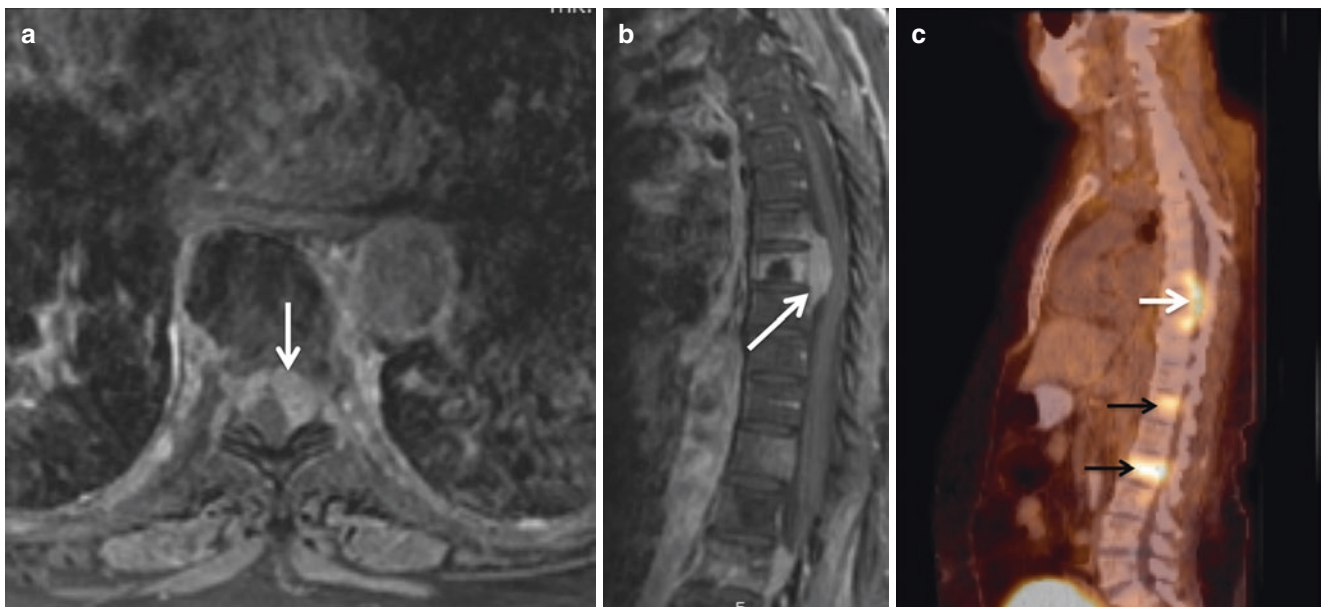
Postcontrast axial T1 MR image (a) and sagittal postcontrast T1 MR image of the thoracic spine (b) depict an enhancing mass arising from the T7 vertebra and extending into the epidural space (white arrows). There is associated severe cord compression. A single fused
